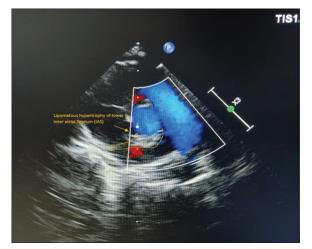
Lipomatous hypertrophy of lower inter atrial septum (IAS) in parasternal short axis (PSAX) view
